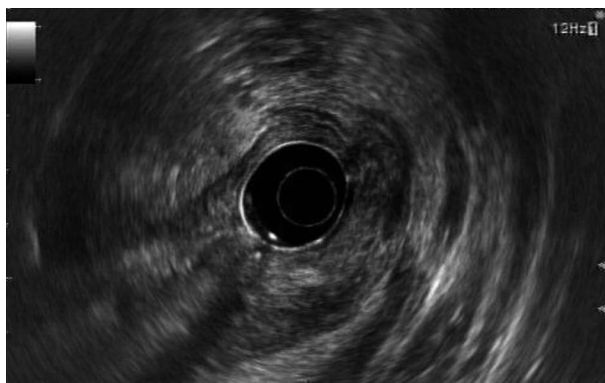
Endosonographic views. A lobulated mass measuring about 5 cm with mixed echogenicity and an irregular margin was observed at the gastric antrum.
